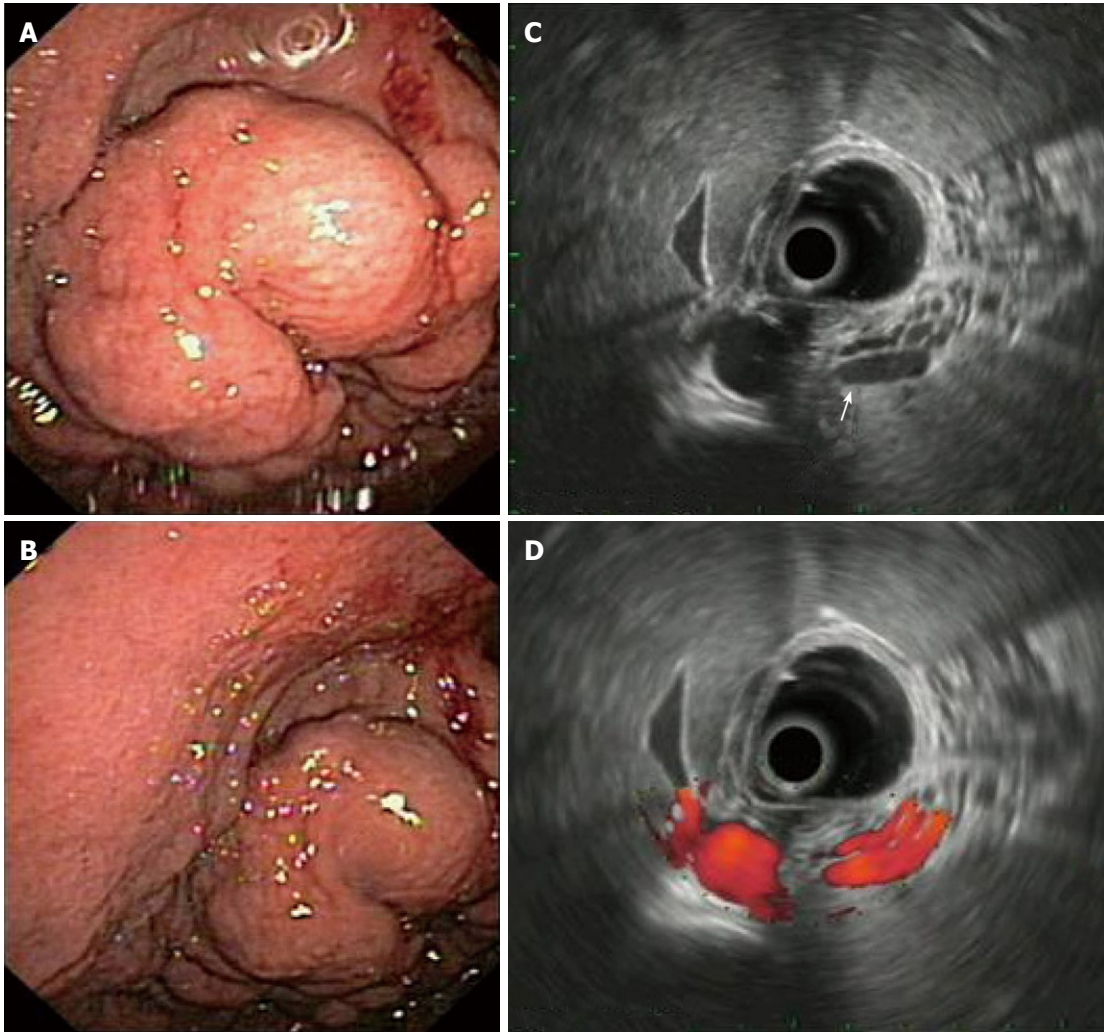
Gastric varices in endoscopy and endoscopic ultrasonography. A, B: Endoscopic image of gastric varices presenting as thick serpiginous structures, covered by normal mucosa; C: EUS imaging of the varices; note their tortuous, anechoic structure which originates from the 3rd layer, i.e. the submucosa (arrow); D: EUS Doppler imaging of the same varices; the positive signal denotes their vascular origin. EUS: Endoscopic ultrasonography.
